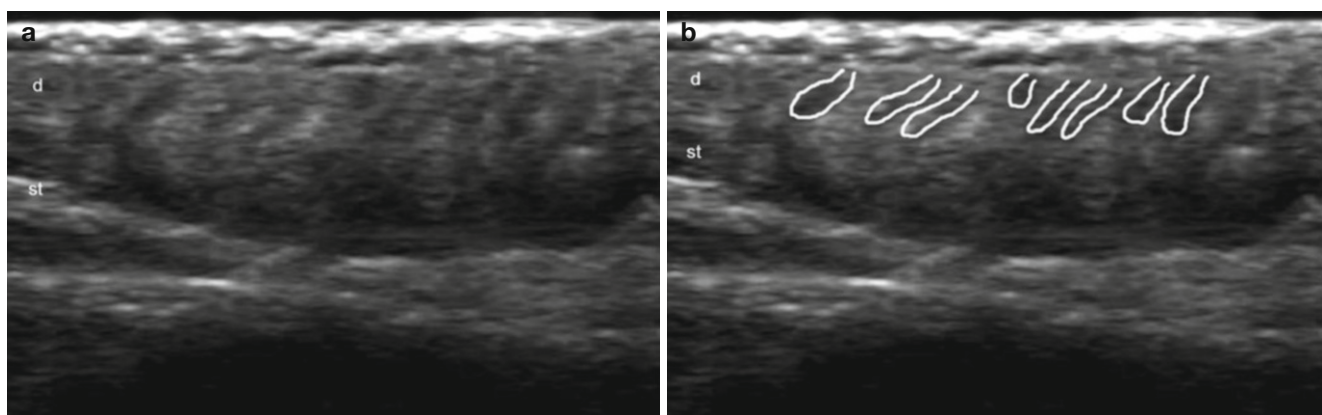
(a–d) Sonoanatomy of the scalp and hair follicles (occipital region). (a, b) Grey scale ultrasound images (scalp); (b) with the hair follicles outlined. (c, d) 3D reconstructions of the hair follicles (axilla);
